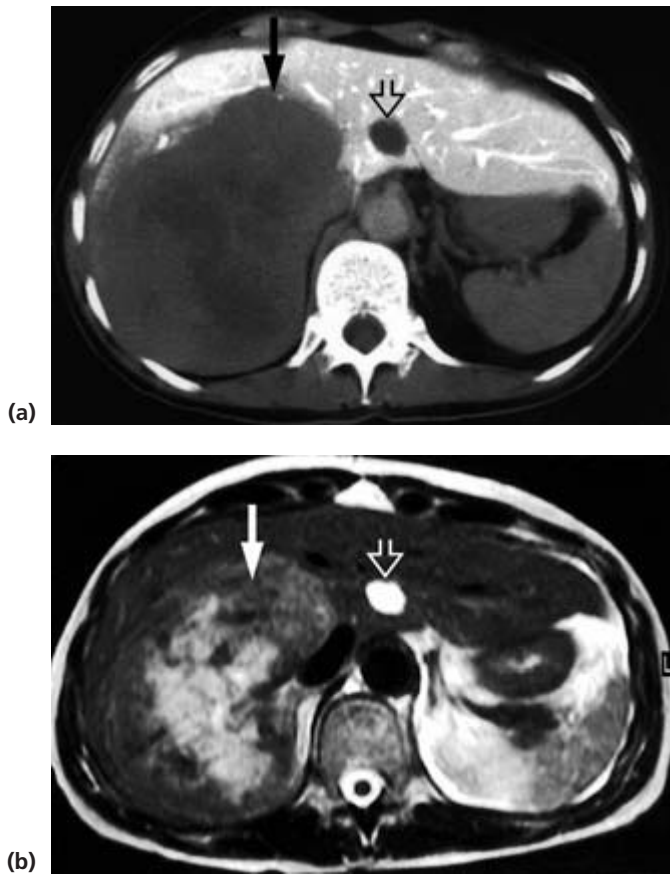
(a) CT arterio-portogram. A large metastasis from a colo-rectal cancer is shown in the right lobe of the liver (arrow). There is a cyst in the left lobe (open arrow). (b) MRI fast spin echo T₂ in the same patient shows the right lobe metastasis (arrow). The simple cyst in the left lobe is shown again (open arrow). (Courtesy of Dr Jon Tibballs.)
